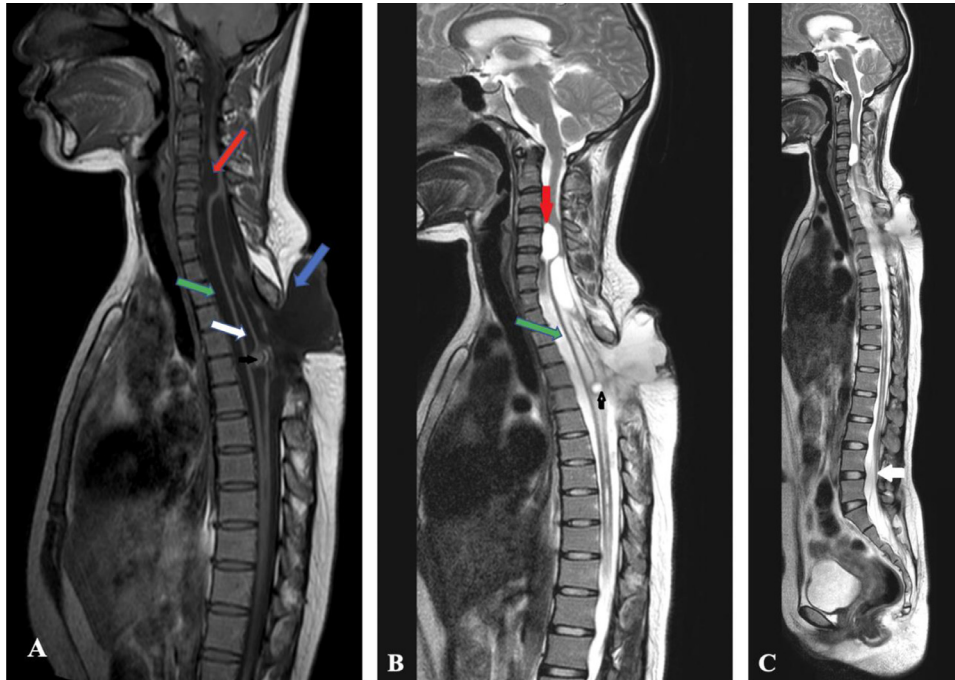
Sagittal MRI images (Figure 2A-T1 weighted image), (Figures 2B, 2C-T2 weighted images) demonstrate CSF-filled cystic protrusion through the neural arch of D5 vertebra which also contains neural elements (blue arrow in Figure 2A). There is an intradural extramedullary CSF-signal intensity lesion adjacent to the C4 and C5 vertebral levels (red arrow in Figures 2A,2B) which has caused indentation in the adjacent spinal cord. In addition, there is dilatation of anterior subarachnoid space spanning from the level of C6 vertebral body to D7 vertebral body (green arrow in figure 2B). A tiny lesion is noted in the central canal of spinal cord at D6 vertebral body level demonstrating intermediate signal intensity on T1 weighted image (black arrow in Figure 2A) and high signal intensity on T2 weighted image (black arrow in Figure 2B) . Furthermore, there is dilatation of central canal of spinal cord (syrinx) spanning from the level of C6 vertebral body to L3 vertebral body (white arrow in Figure 2A). Tethered spinal cord reaching L4-L5 vertebral level is also noted (white arrow in Figure 2C).
